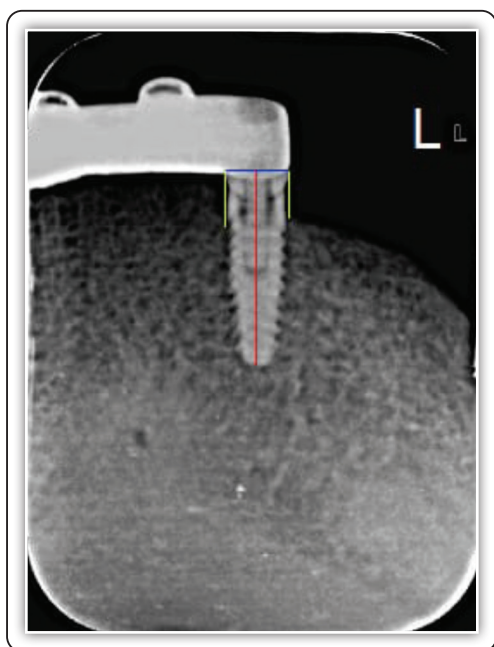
Radiographic reference lines for determining peri-implant vertical bone loss after 5-year of mandibular overdenture insertion.
